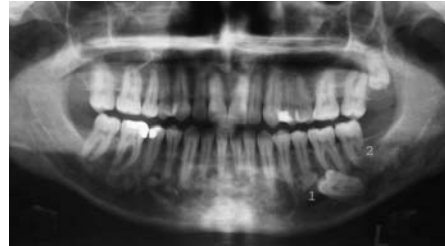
Panoramic radiograph taken at the 1st visit in 2004, showing irregular radioopaque-radiolucent lesions throughout the mandible.
